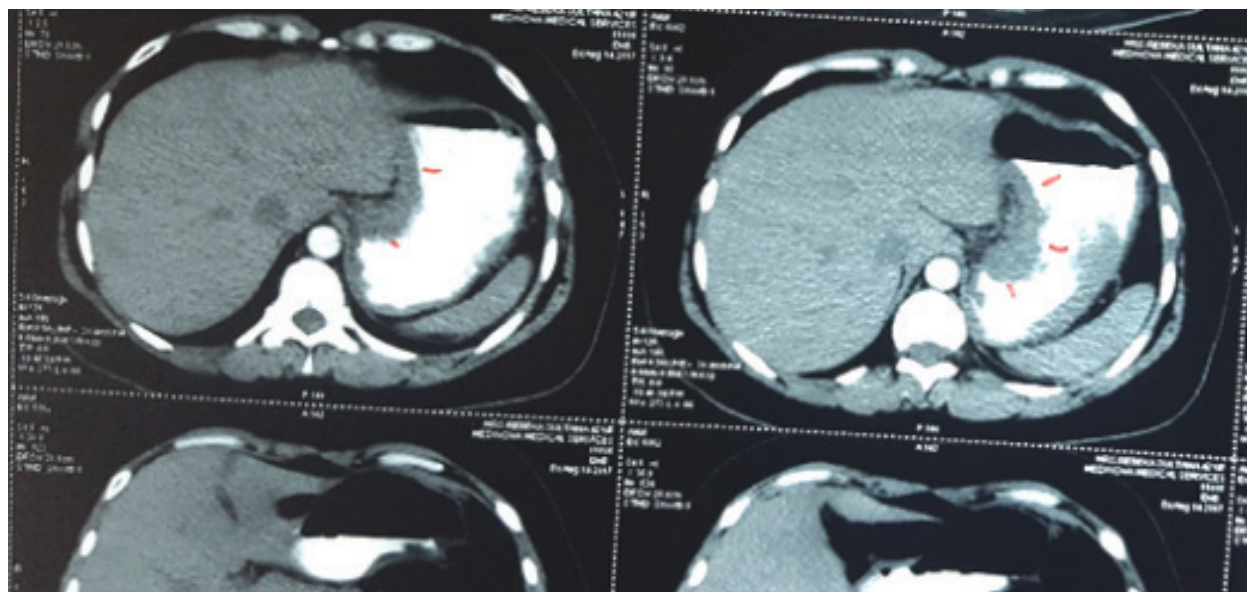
CT Scan delineating stomach with linitis plastica, stomach wall is thickened throughout the length of lesser and greater curvature.
